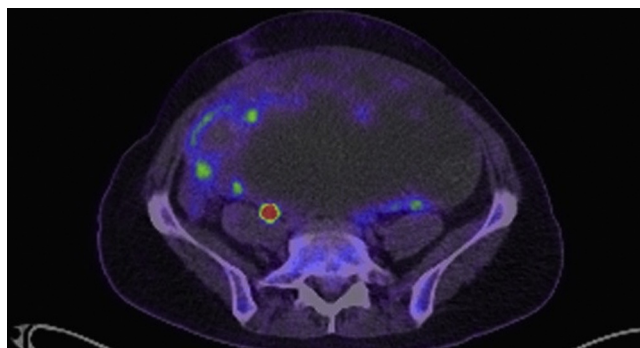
Axial image of FDG PET scan demonstrating patchy uptake at the periphery of the KT and the small FDG-avid mass between the KT and abdominal wall.
